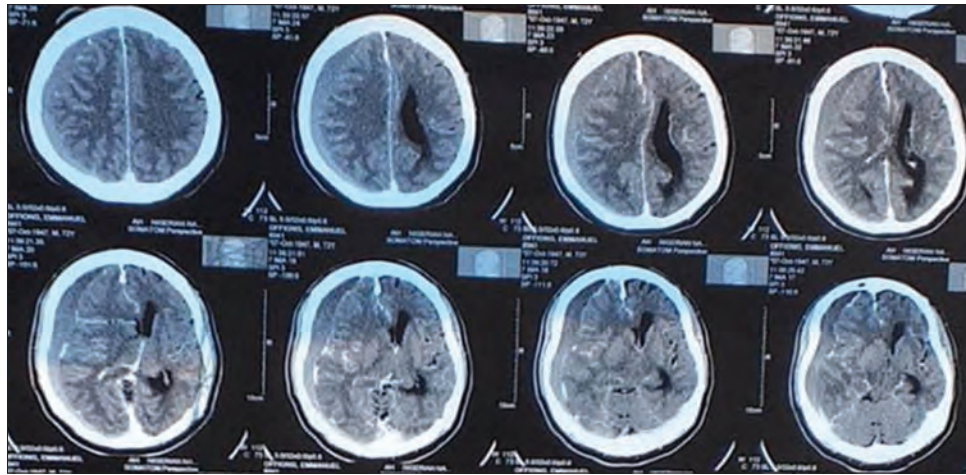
Preoperative computed tomography images showing right chronic subdural hematoma with midline shift and effacement of the ipsilateral lateral ventricle
